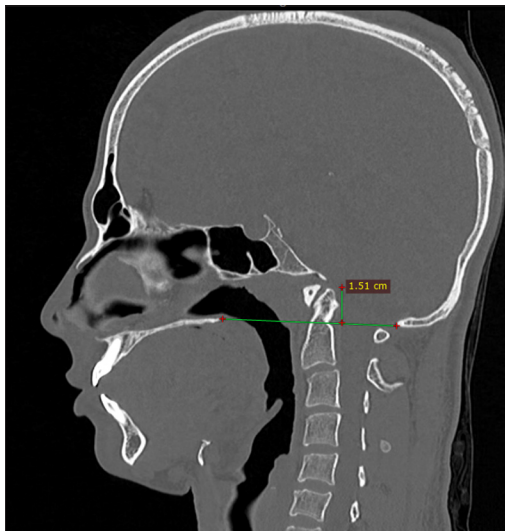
Sagittal computed tomography image of the skull with the craniovertebral junction shows the tip of the dens projecting 15.1 mm above the Chamberlain line, suggestive of basilar invagination.
